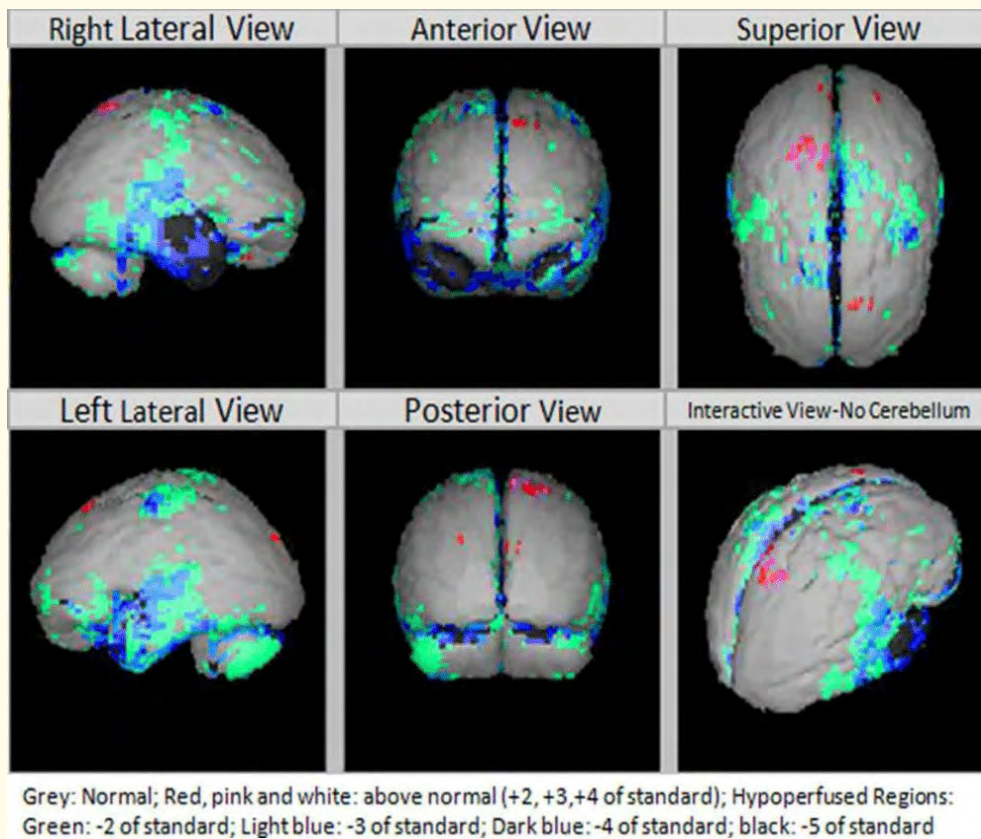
SPECT Scan of a Parkinson's disease Patient before Therapy Showing Hypo perfused Regions.
